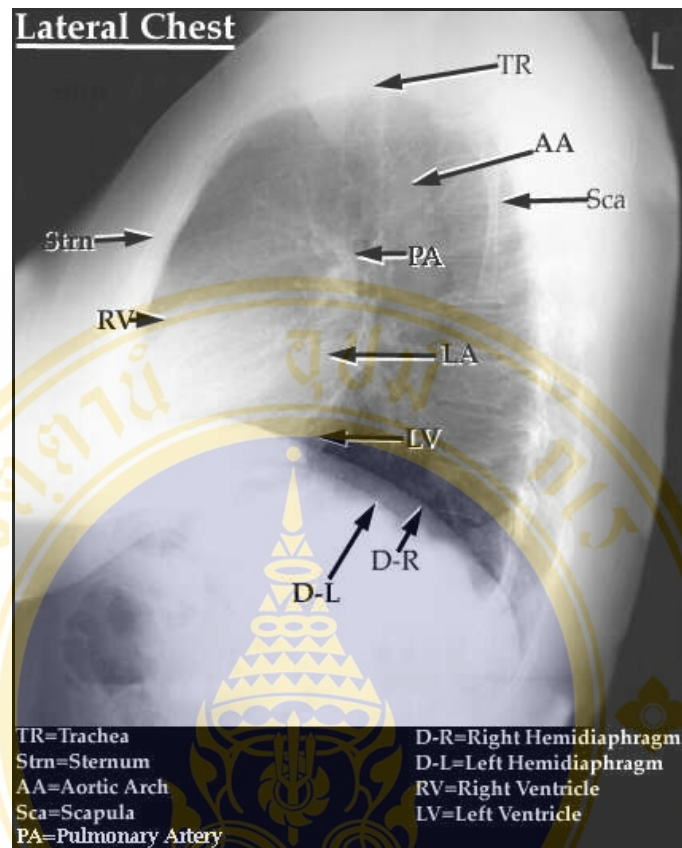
Normal lateral chest radiography
